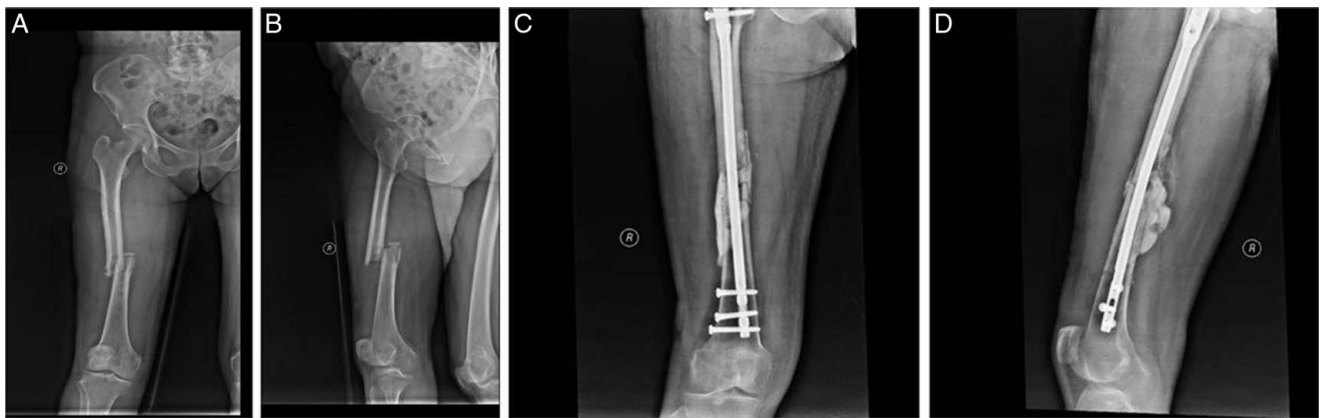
(A, B) Show preoperative X-ray examination. (C, D) are postoperative re-examination.
